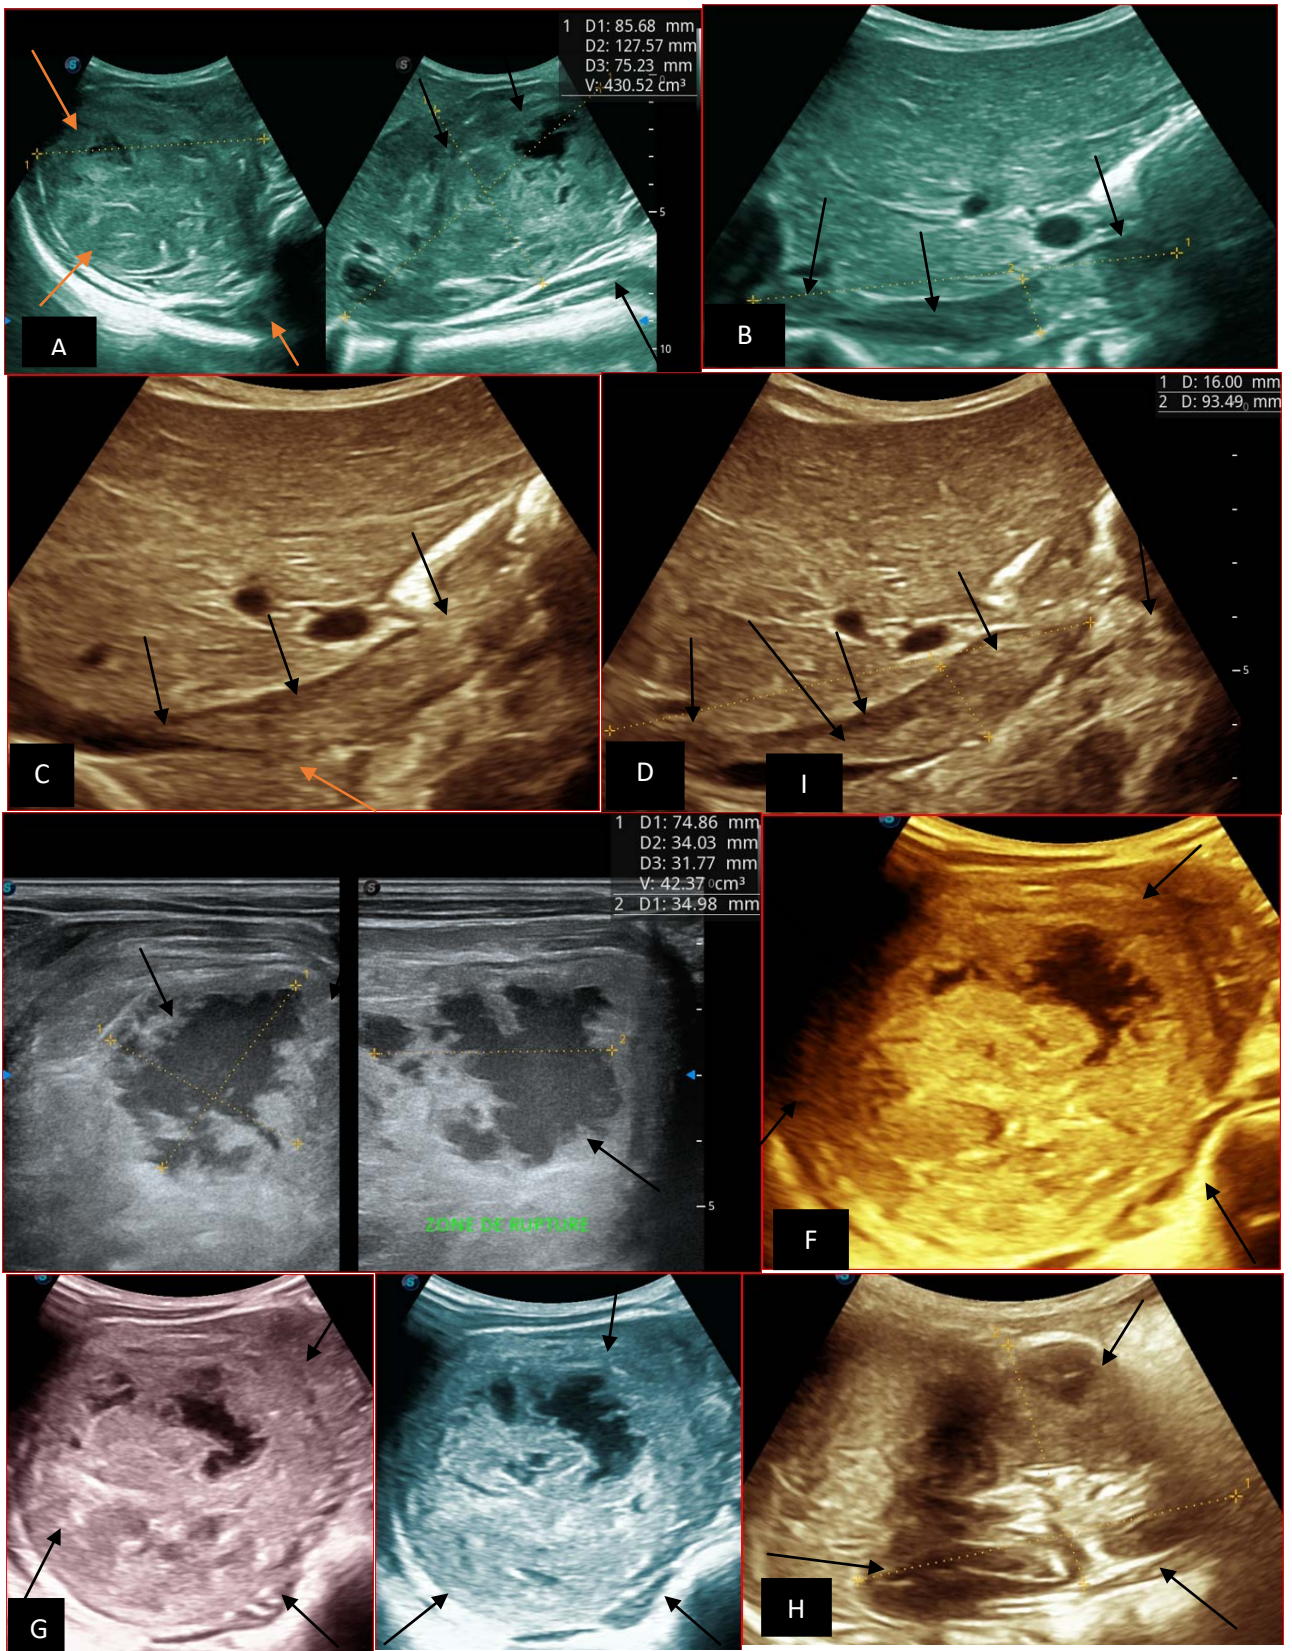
Abdominopelvic ultrasound control after 6 courses of chemotherapy in the same 3 year old patient with a ruptured left renal nephroblastoma; Images A, F, G, and H: show regression of the solid, endo and exo renal, left nephroblastoma mass treated with 6 courses of chemotherapy (current volume 430 ml vs) Images: B, C, and: show persistence of thrombotic permeation pan vena cava and ipsilateral renal. Image E: shows a volumetric regression of the intra-lesional hematic collection, at the tumor rupture estimated at 34.49 ml VS, Image I: represents the right kidney in B mode which is of normal echostructure. Source : Dr. Frederick Tshibusu Tshienda database.
